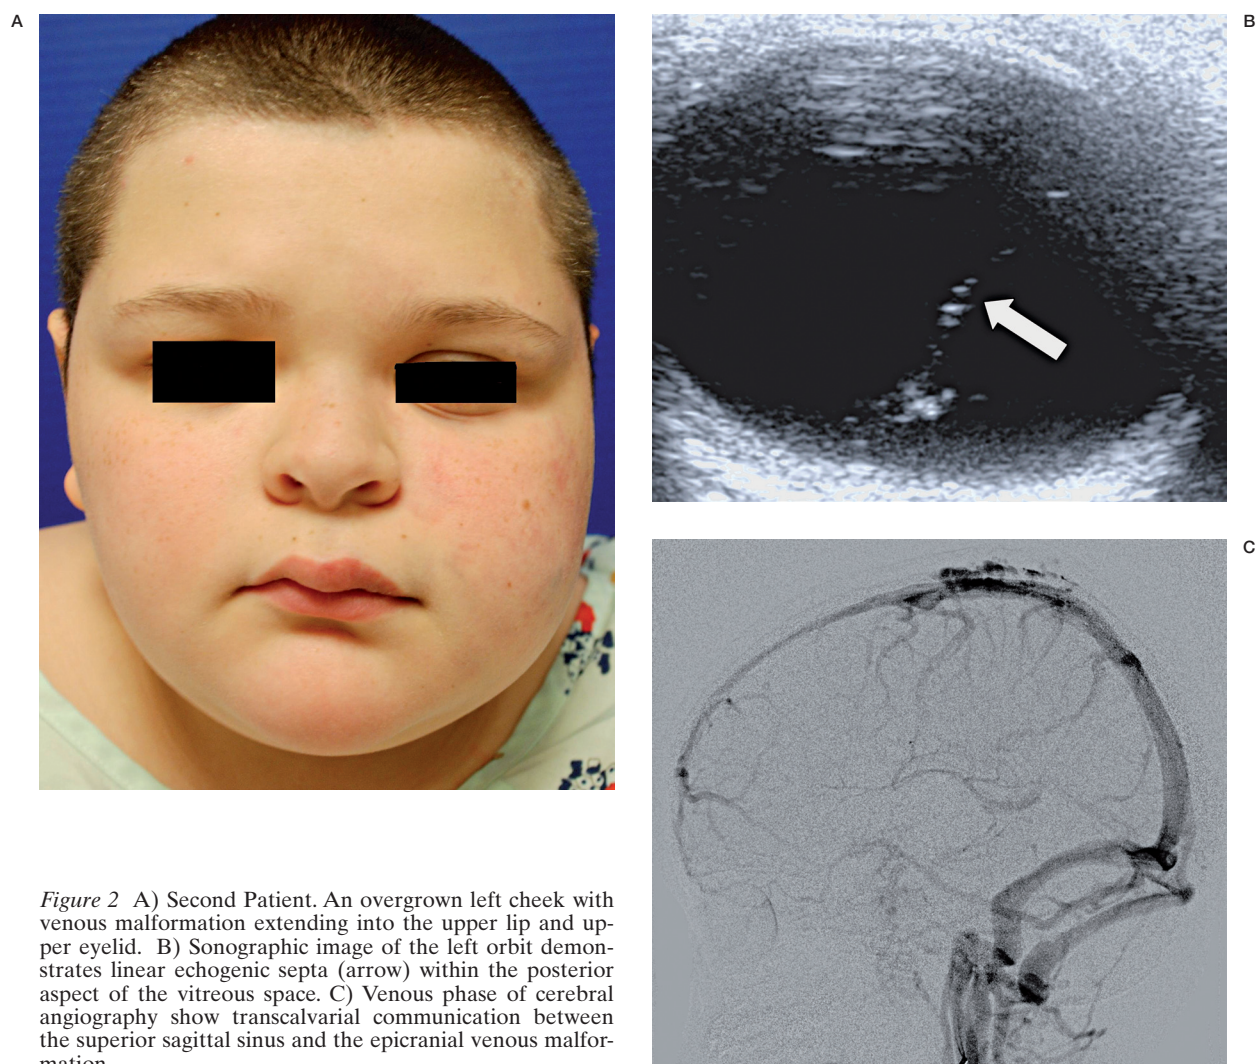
A) Second Patient. An overgrown left cheek with venous malformation extending into the upper lip and upper eyelid. B) Sonographic image of the left orbit demonstrates linear echogenic septa (arrow) within the posterior aspect of the vitreous space. C) Venous phase of cerebral angiography show transcalvarial communication between the superior sagittal sinus and the epicranial venous malformation.
